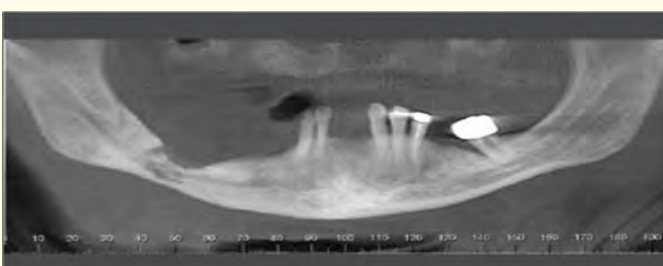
Panoramic radiograph showing extensive involvement of the mandible, with bone lesion in the right posterior portion.
